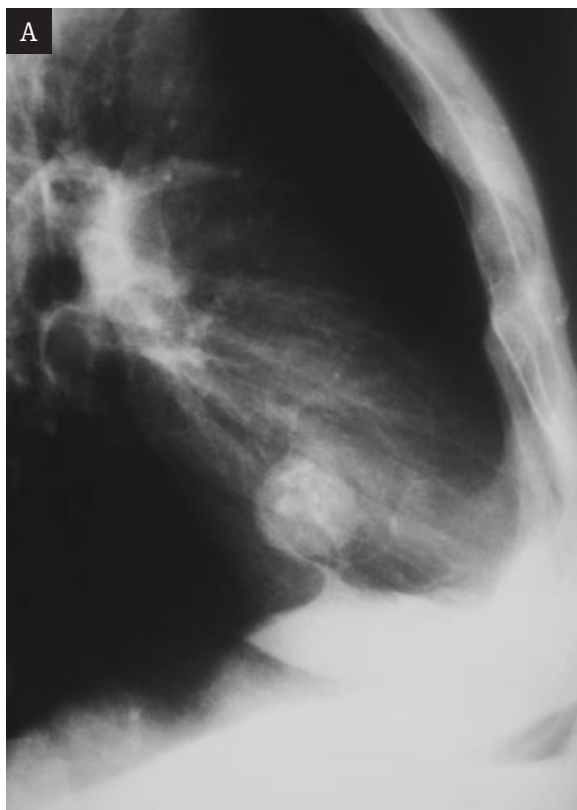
Typical X-ray image of the pulmonary Hamartoma.
